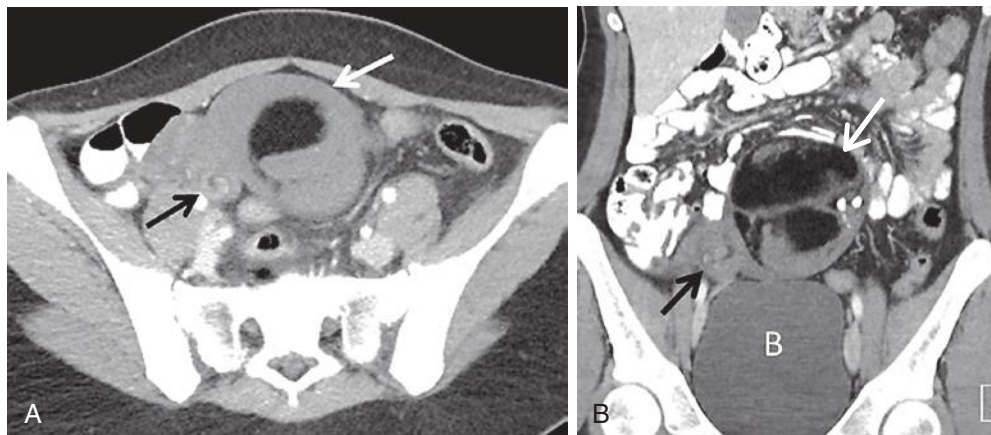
Computed tomography (CT) findings in ovarian torsion associated with mature cystic teratoma. A, Axial contrast-enhanced CT image demonstrates large fat-containing mass (white arrow) located anteriorly in the midline of the upper pelvis. Note twisted vascular pedicle (black arrow). B, Coronal reformatted image shows the large mature cystic teratoma (white arrow), containing fat and calcifications, in the midline superior to the bladder (B) and the twisted vascular pedicle (black arrow).
